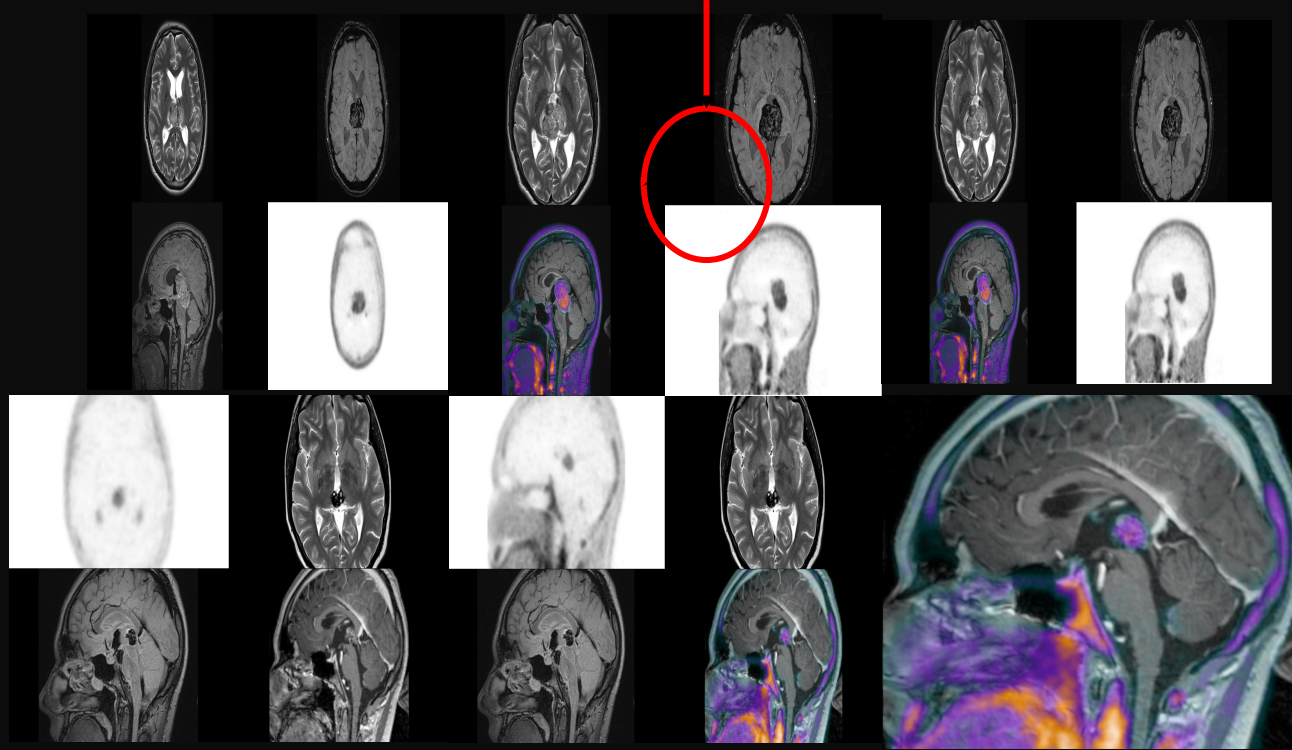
Combined $[^{68}\text{Ga}]\text{-DOTATOC}$ PET/MRI (a) and corresponding PET/CT (b) of a 67-year-old meningioma patient. c IMRT treatment plan, where T2-MRI information as well as DOTATOC uptake were used to create the gross target volume (GTV). PET/MRI, PET/CT and planning CT were registered using a rigid image fusion algorithm which is based on mutual information. Planning target volume (PTV, red contour) was prescribed 60 Gy.
